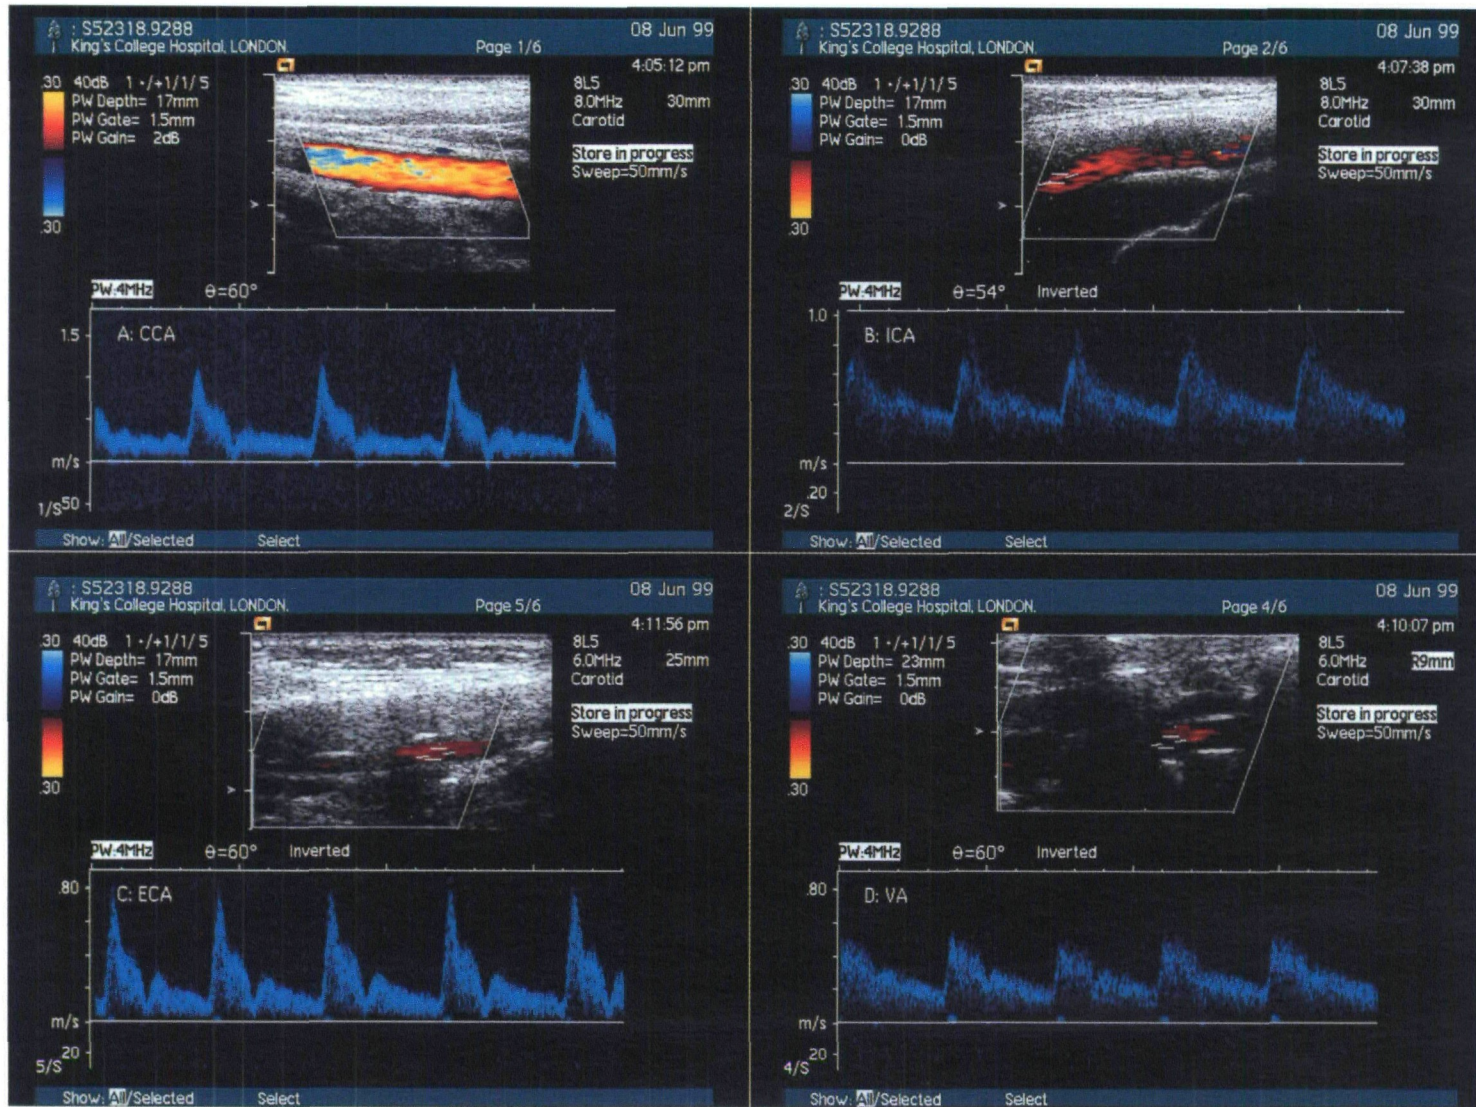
Normal spectral Doppler waveform patterns (A) Common carotid artery (CCA). (B) Internal carotid artery (ICA) (C) External carotid artery (ECA). (D) Vertebral artery (VA)
